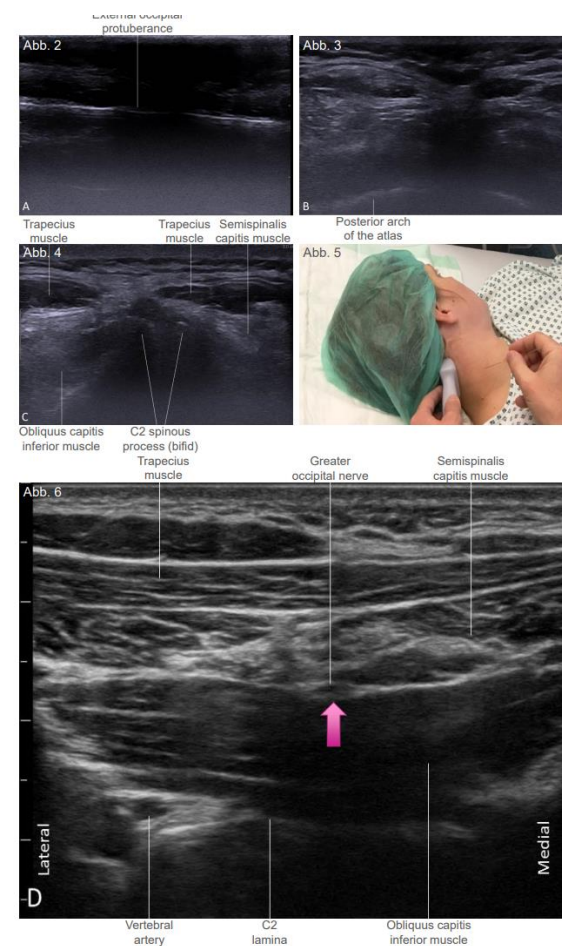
Sonographie zur Darstellung des N. occipitalis major. Abb. 1: zum systematischen Auffinden des N. occipitalis major in Rückenlage mit Kopfdrehung. Abb. 2-4: Darstellung des N. occipitalis major in proximaler Technik. © M. Greher
